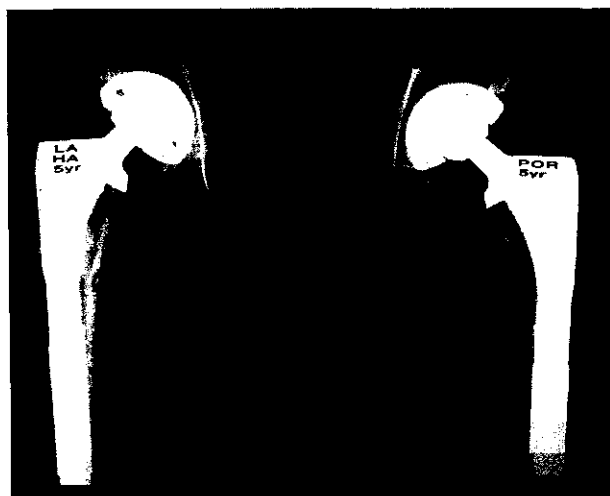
Radiograph of bilateral total hip arthroplasties 5 years after surgery. The right hip has a hydroxyapatite-coated stem which shows cancellous hypertrophy both medially and laterally at the base of the porous coating (buttress sign). The left hip is a porous-coated-only stem with no evidence of the buttress sign. At the junctional corner of the collar and the medial porous coating is smooth metal (between the porous coating on the collar and the medial porous coating). At this junctional corner in both hips can be seen an area of bone loss from stress shielding by failure of the bone to attach to the smooth metal.
